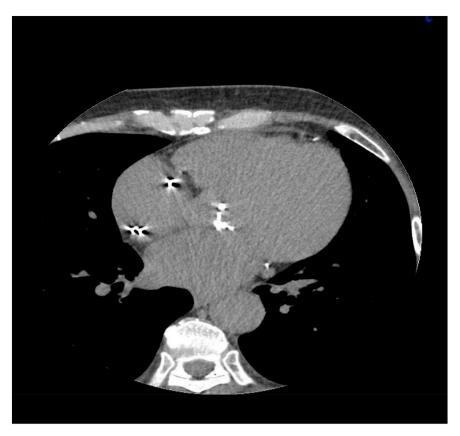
CT revealing significant aortic calcification.
